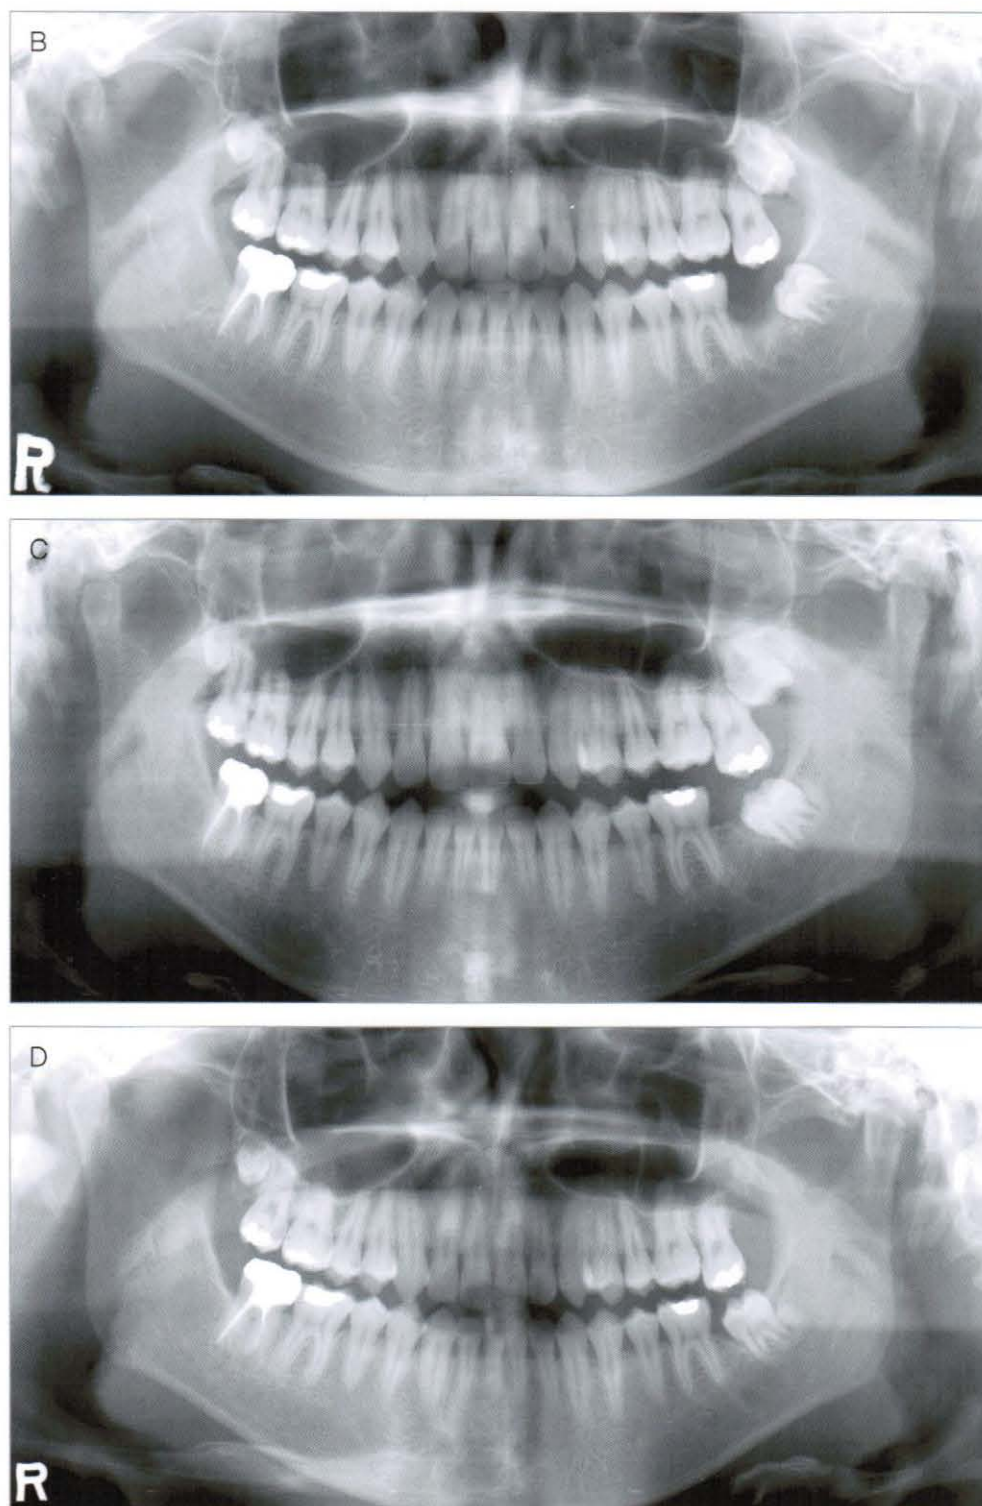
Panoramic radiograph which shows the patient's dental history
